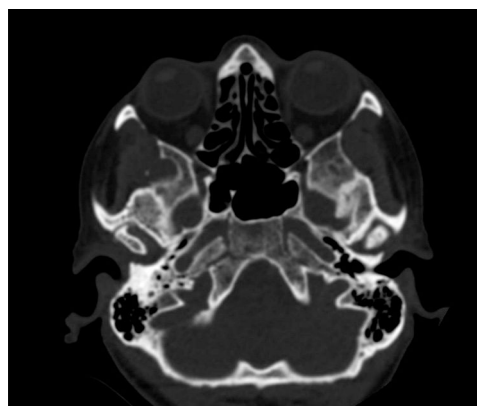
CT scan showing condylar deformity with osteosclerosis, flattening and osteophytes.
